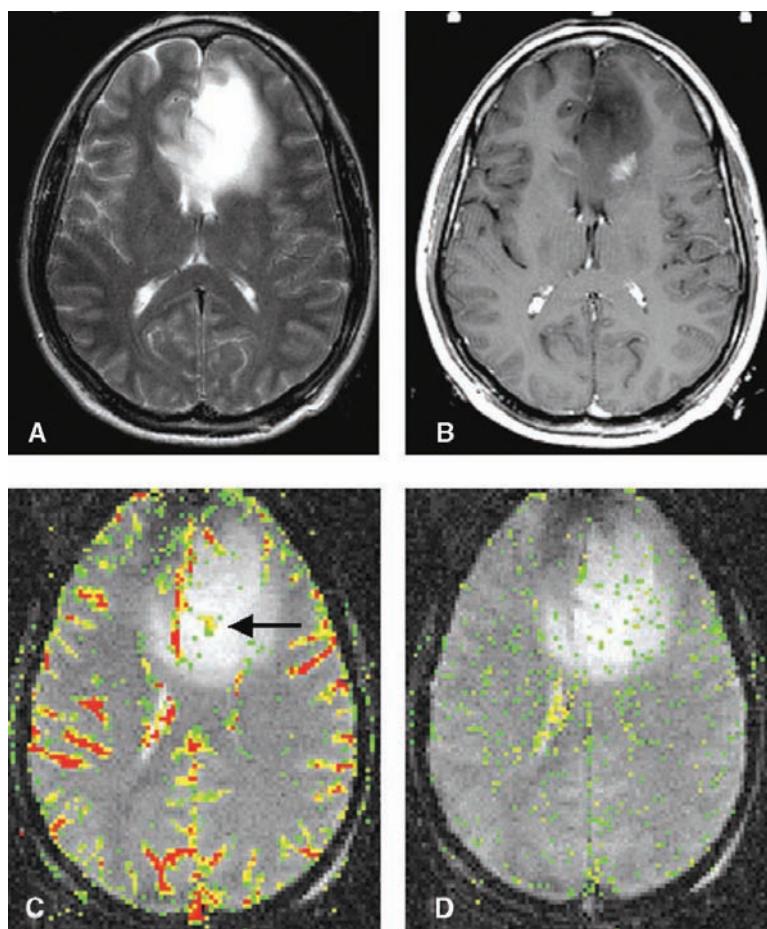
A 30-year-old woman with a low-grade astrocytoma (WHO Grade II). (A) T2-weighted image demonstrates bifrontal signal abnormality, centered primarily in the left frontal lobe. (B) T1-weighted postgadolinium image demonstrates an ill-defined focus of enhancement in the posterior aspect of the lesion. (C) Gradient-echo axial DSC MRI with (rCBV) color overlay map demonstrates a few foci of mildly elevated perfusion (arrow) that is seen in a different location to the region of maximal enhancement in Figure 2 (B). (D) SD25 color overlay map suggests low vascular permeability throughout the lesion. Abbreviations: rCBV, relative cerebral blood volume; DSC MRI, dynamic susceptibility contrast MRI. Source: From Ref. 28.
